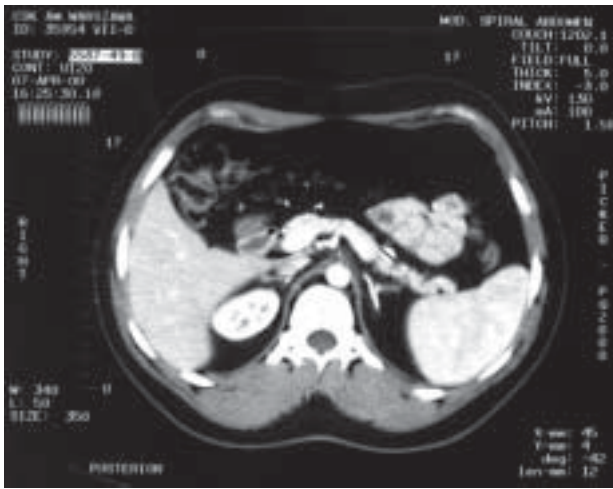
Computed tomography of the abdomen showing single lesion in the pancreas
